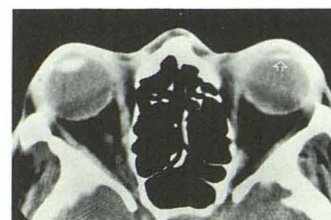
Axial CT scan of head at level of midorbits shows characteristic features of an intraocular prosthetic lens (arrow) in left globe. Lens in right globe is normal.
